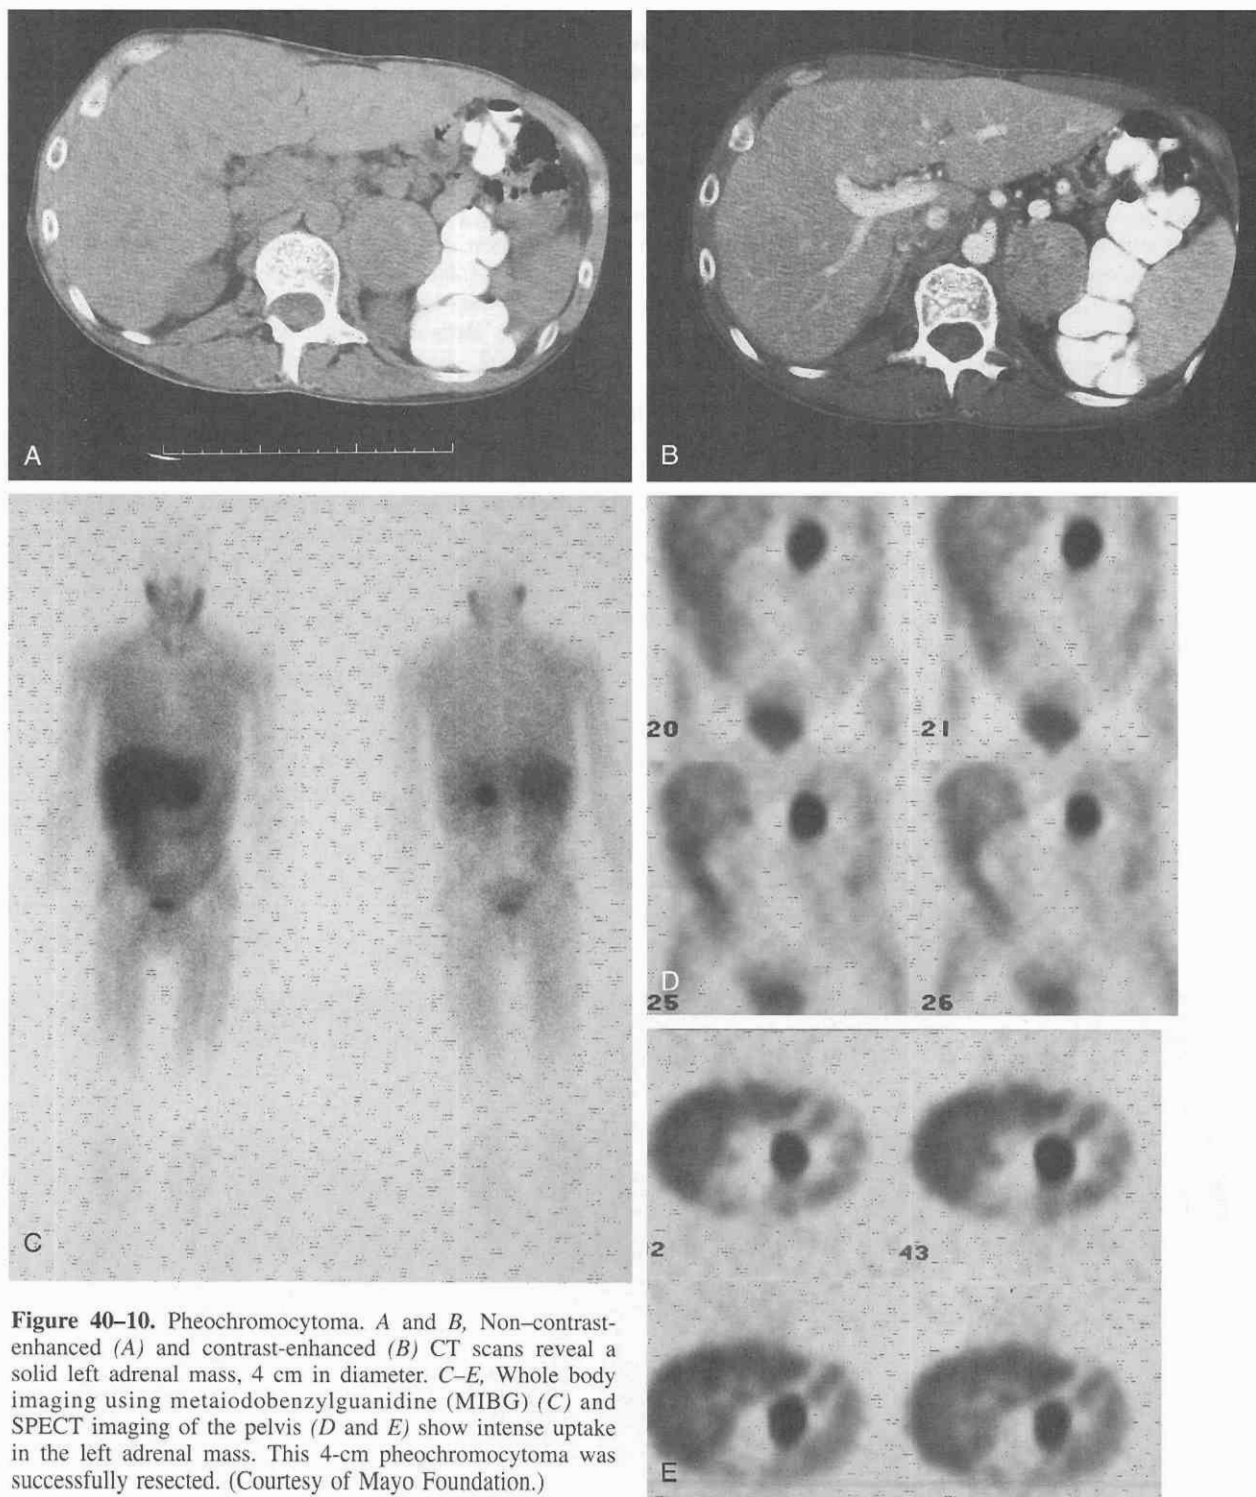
Pheochromocytoma. *A* and *B*, Non-contrast-enhanced (*A*) and contrast-enhanced (*B*) CT scans reveal a solid left adrenal mass, 4 cm in diameter. *C–E*, Whole body imaging using metaiodobenzylguanidine (MIBG) (*C*) and SPECT imaging of the pelvis (*D* and *E*) show intense uptake in the left adrenal mass. This 4-cm pheochromocytoma was successfully resected. (Courtesy of Mayo Foundation.)
